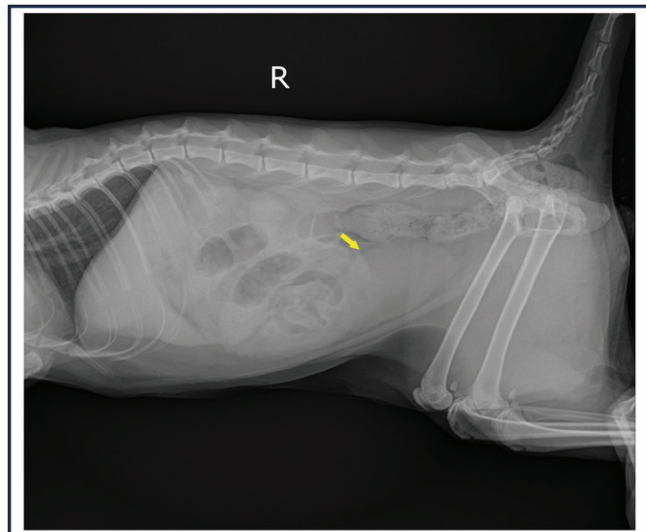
Preoperative abdominal radiography revealed urinary bladder distention (arrow). No other factors contributing to urinary blockage were detected
